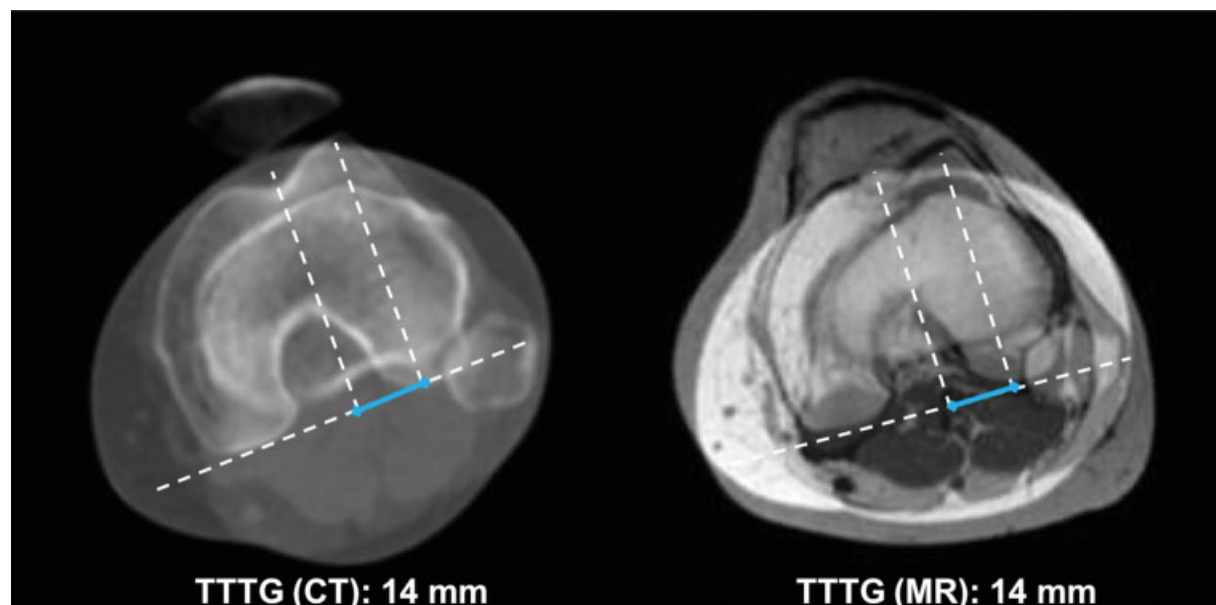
The image shows the superimposed CT (left) and MRI (right) slices and depicts the TT-TG measurement in the left knee of a 29-year-old female asymptomatic volunteer.
